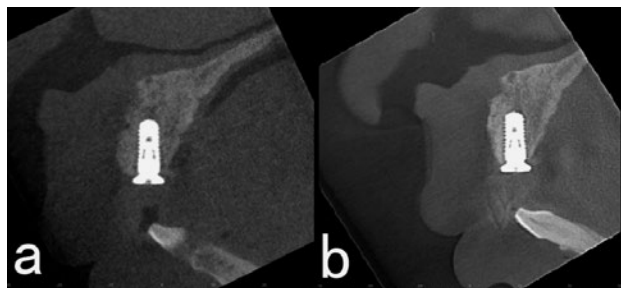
CBCT sagittal view of implant placement simultaneous to GBR (a) immediately and (b) 8 months after surgery.
